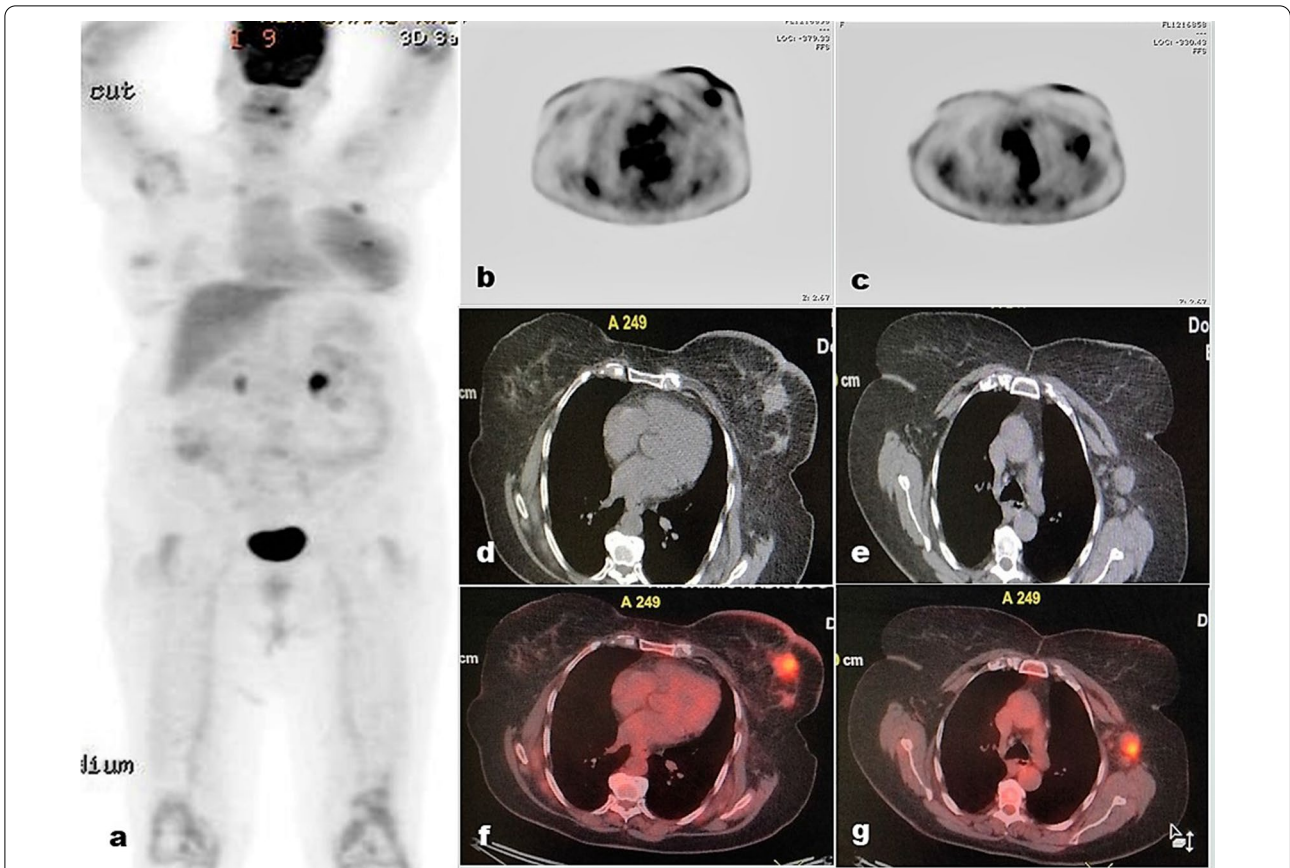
60 years old patient with recently diagnosed left sided HER2 positive breast carcinoma. TLR= 2 and TSR= 2.2 a Maximum intensity projection. b and c Trans axial PET images corresponding axial CT cut in d and e shows left breast retro-areolar isodense soft tissue mass lesion associated with skin thickening. It measures about 5 × 4 cm associated with enlarged suspicious looking left axillary lymph node. It measures about 2 × 1.7 cm. f fused PET/CT axial cut shows left breast retro-areolar FDG avid lesion displaying SUV_{max} ~4.7. g fused PET/CT axial cut show FDG avid axillary lymph node displaying SUV_{max} ~4.8
